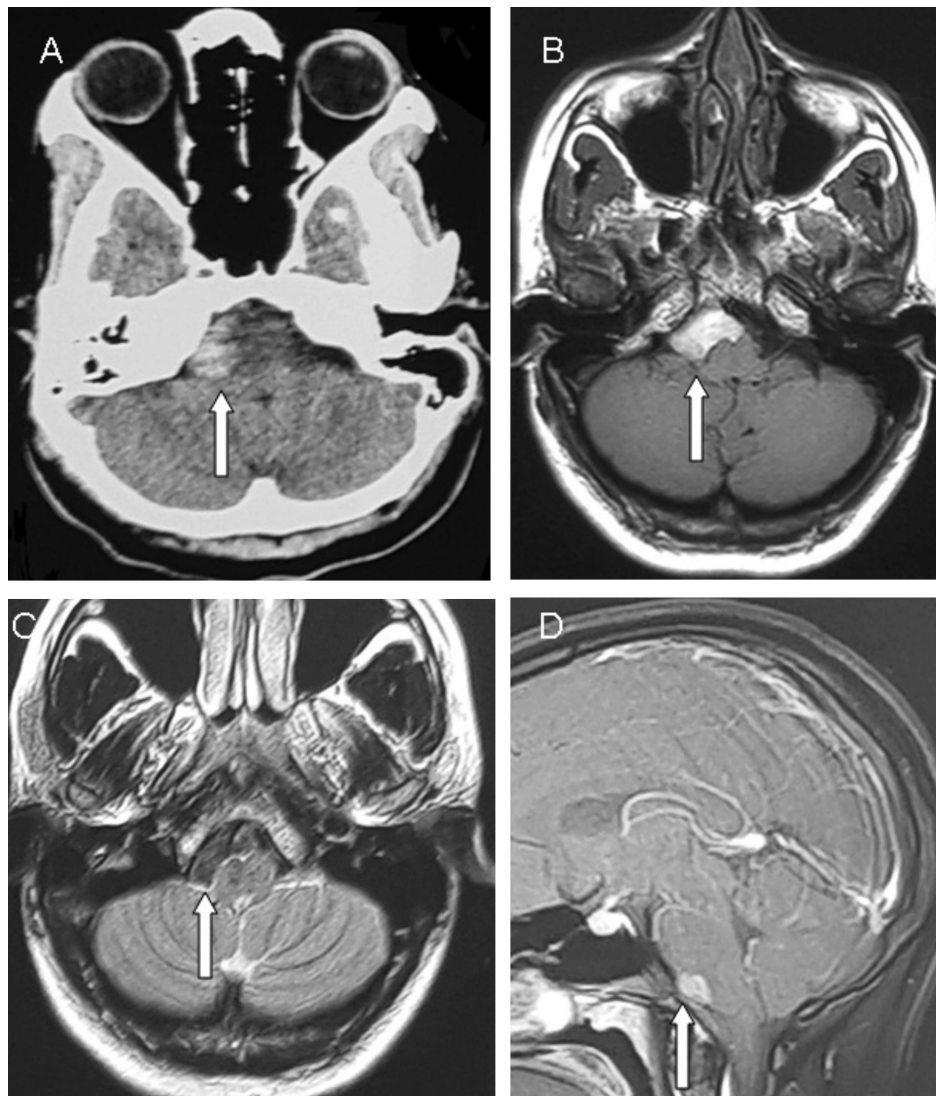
Computed tomography and magnetic resonance imaging of white epidermoid cyst. A) Axial computed tomography shows a well-defined hyperdense extra-axial lesion in right cerebellopontine angle. B) Axial T1-weighted magnetic resonance imaging shows a well-defined hyperintense extra-axial lesion in right cerebellopontine angle. C) Axial T2-weighted magnetic resonance imaging shows loss of signal on T2-weighted images (cerebral shading sign) in the lesion. D) Sagittal T1-weighted magnetic resonance imaging shows no contrast enhancement in the lesion
